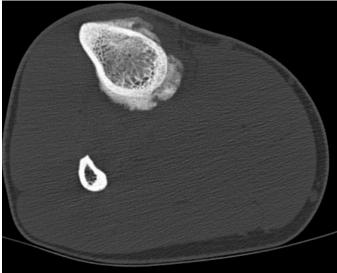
Axial CT showing the periosteal reaction.
